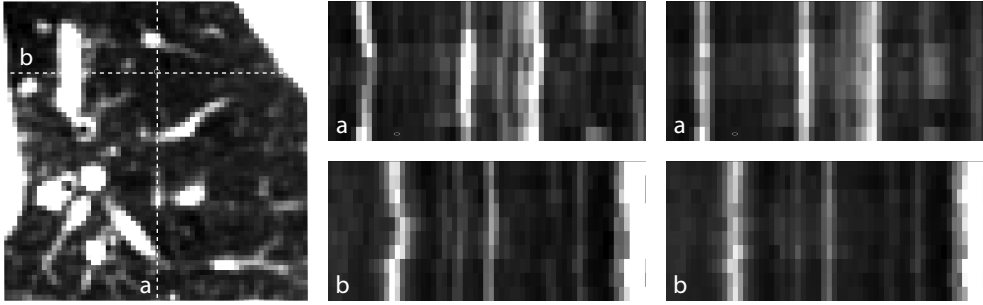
Registration result for a 3D+t CT image of the lungs. Left and middle: input image. Right: registration result. Image (a) and (b) show the dotted lines in the left image over time.
